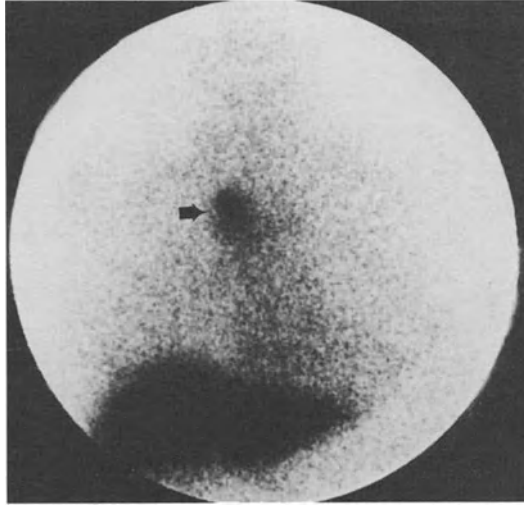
SPECT slices of the liver. C, D: At this dose all metastatic lesions of soft tissue and bones were detected at a higher rate than other dose levels. In this patient, a metastatic lesion is noted in the left lung (arrow).
